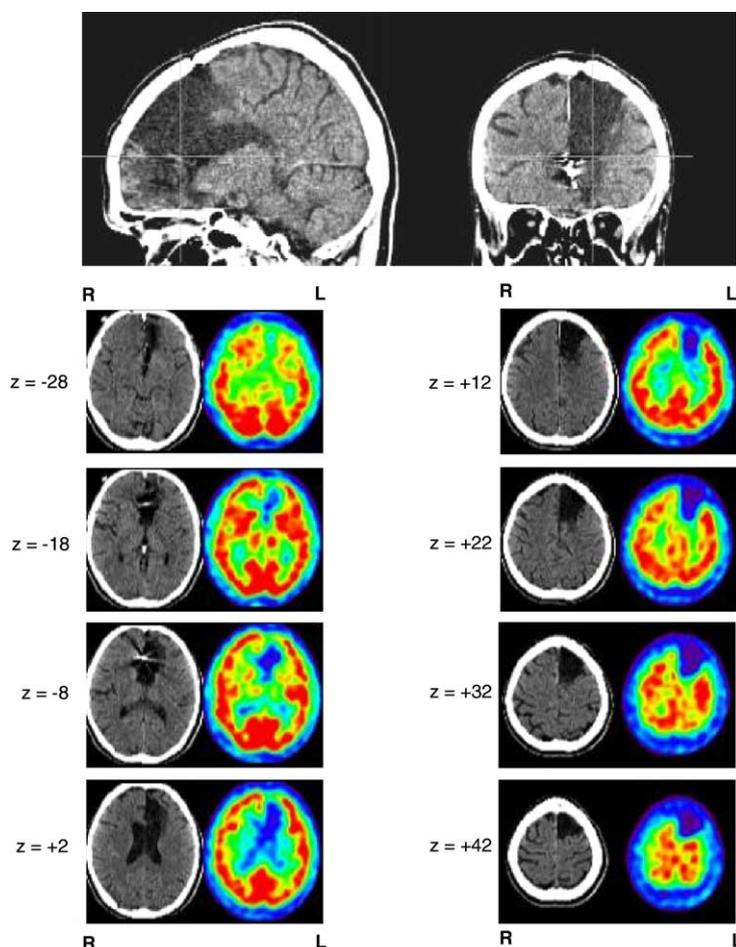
Anatomy of patient RMB's lesion. Sagittal and coronal sections of a high resolution brain CT-scan ($0.39 \text{ mm} \times 0.39 \text{ mm} \times 1 \text{ mm}$), and eight axial sections of CT-scan and rest SPECT normalized in Talairach's space using SPM2 (z coordinate is provided for each pair of sections) reveal a stroke lesion delineating part of the left anterior cerebral artery territory. Only the rolandic part of this arterial territory is spared, in accordance with the clinical examination confirming the absence of right motor limb deficit.
